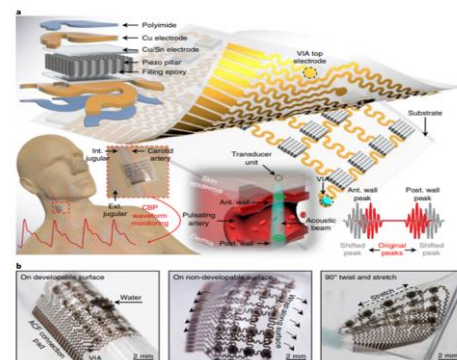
Design and mechanism of the tensile ultrasound machine
